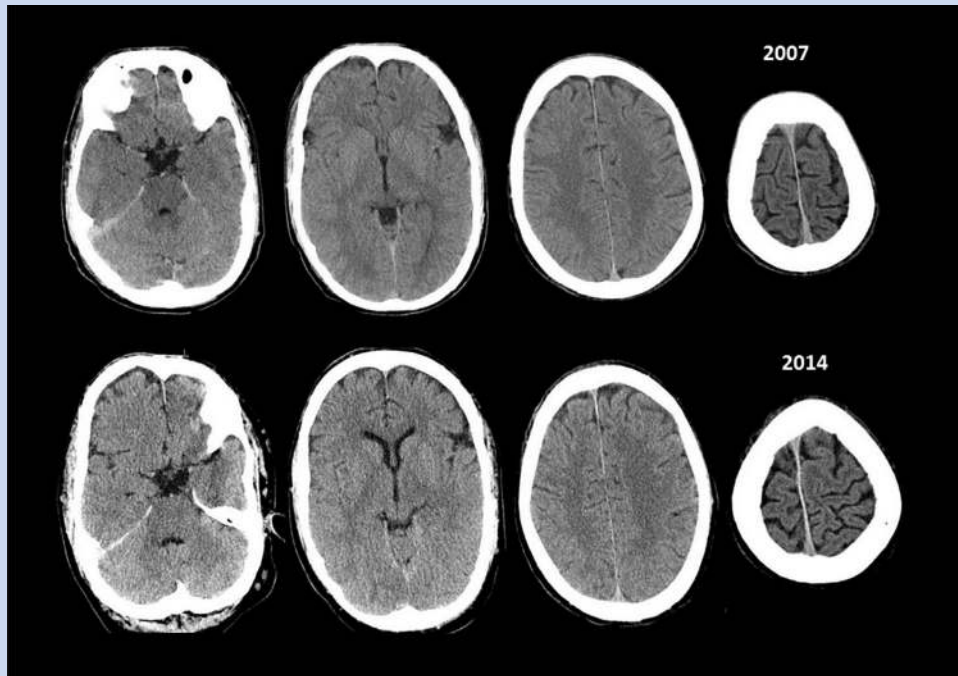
Brain CT scans suggesting subtle change in the cortical volume after 7 years follow-up.
